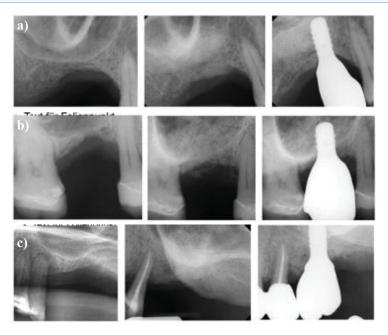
Triplicates of periapical x-rays at baseline, 6 months after SFE & 12 months after loading.
